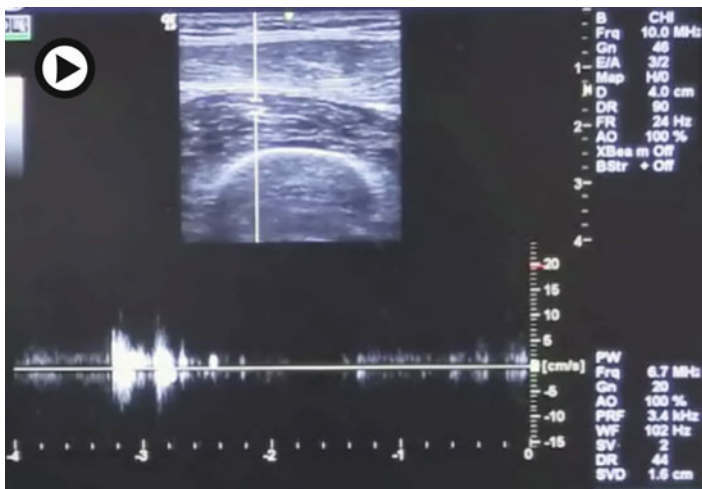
(Video 11.4) Stretch reflex with B mode (transverse view) and Doppler mode insonating the vastus intermedius (▶ <https://doi.org/10.1007/000-7qw>)
